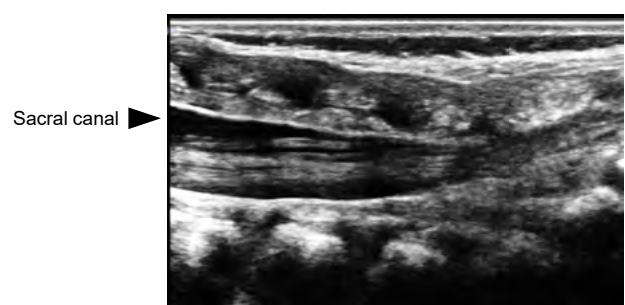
Longitudinal ultrasound view of the sacrum
